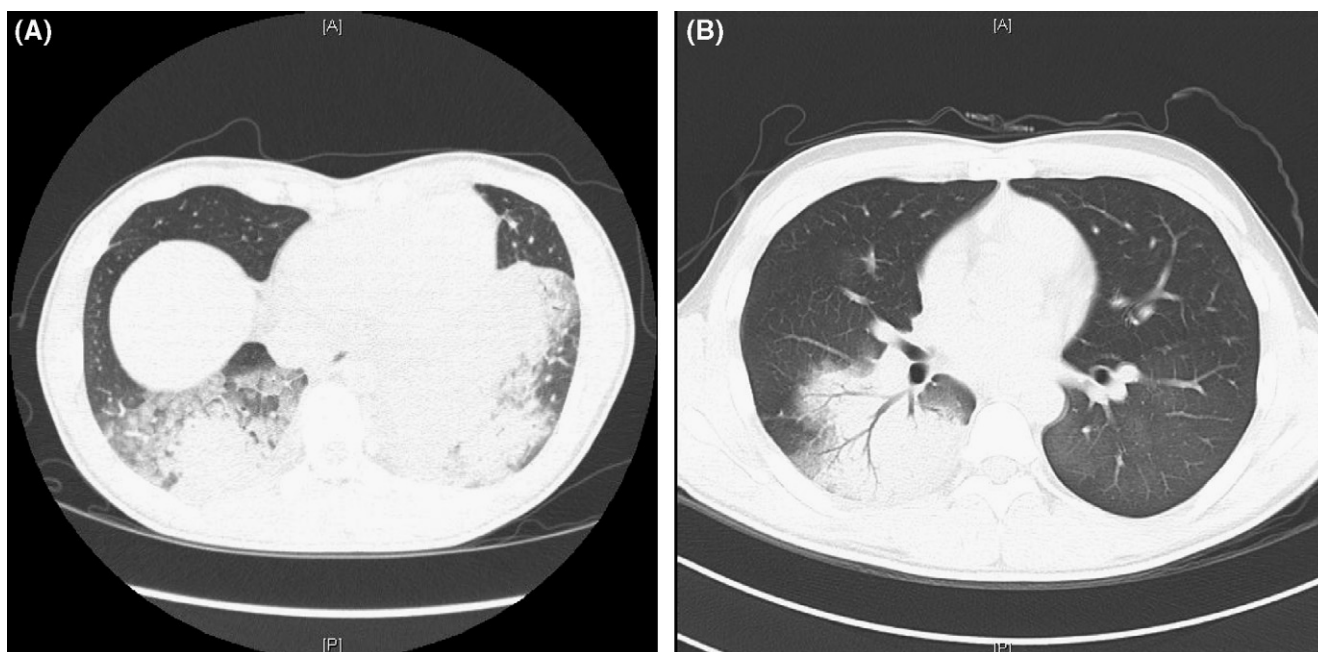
(A) HRCT scans in a 16-year-old boy with ARDS due to adenovirus which showed bilower lobe consolidation, ground-glass opacity and left pleural effusion; (B) HRCT scans in a 18-year-old boy with adenovirus pneumonia but without ARDS showed right lower consolidation.
